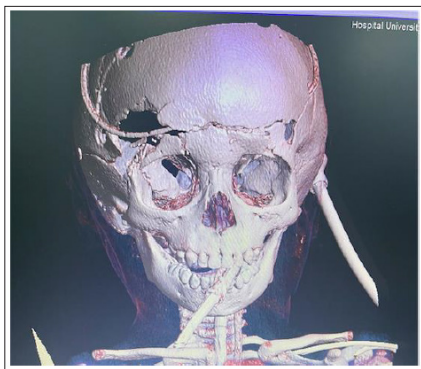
Post Operative Skull CT
